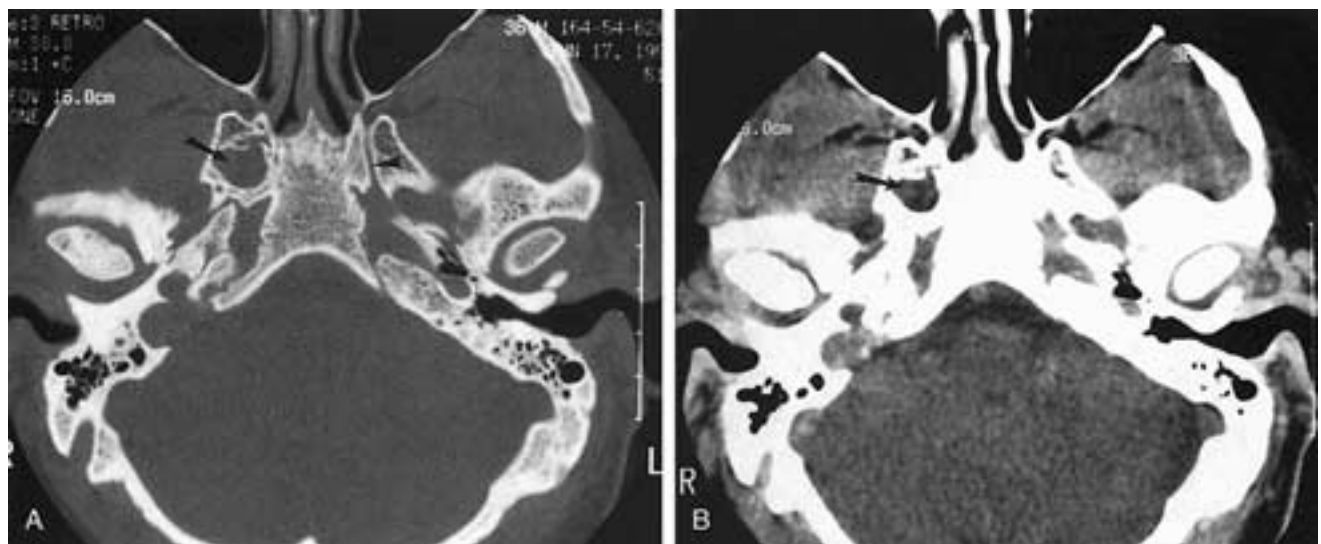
Normal variant in the sphenoid. A, Axial CT bone algorithm shows what appears to be a dilated cystic structure in the pterygoid process (*arrow*). The normal pterygoid (Vidian) canal is seen (*arrowhead*) on the opposite side. B, Soft-tissue algorithm shows that the area within this cystic structure contains fat, indicating that this represents a variation in ossification rather than obstructed secretions.
